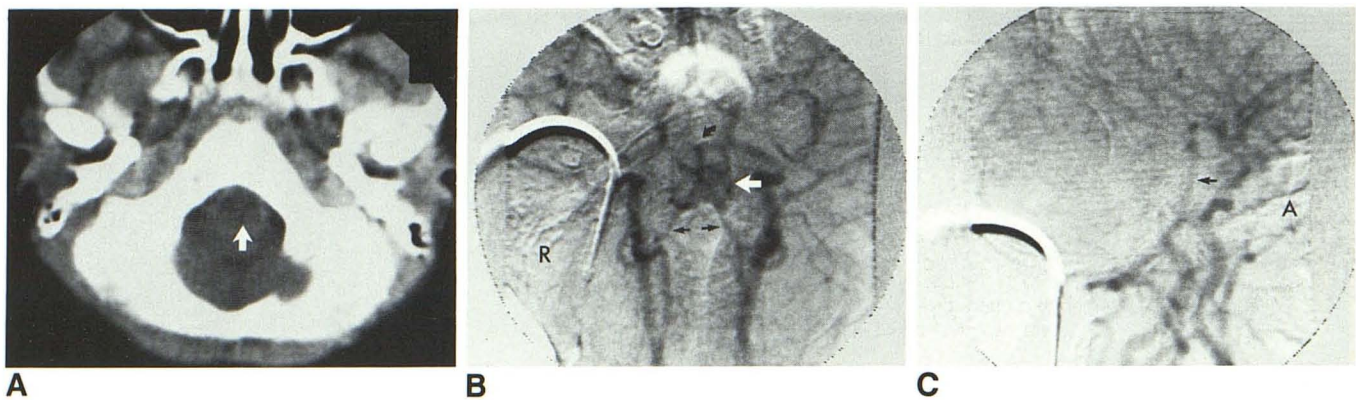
A, Axial CT. Low-density region in brainstem consistent with infarction (arrow). B, Basal view. Arterial phase of IV digital subtraction angiogram showing vascular blush in brainstem secondary to luxury perfusion (white arrow). Small arrows = vertebral arteries; curved arrow = basilar artery. R =
